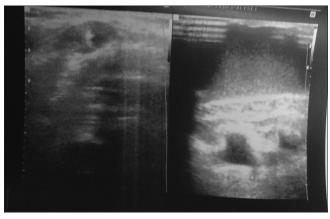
Ultrasound showing breast lesion resolved
